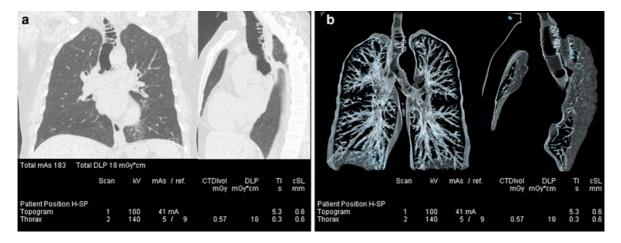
Low-Dose chest CT examination obtained in a patient weighting 65 kg with the same parameters as in Fig. 14 but with a mean effective tube current time product of 5 mAs. The CTDIvol is of 0.57 mGy and the DLP of 18 mGy.cm.
